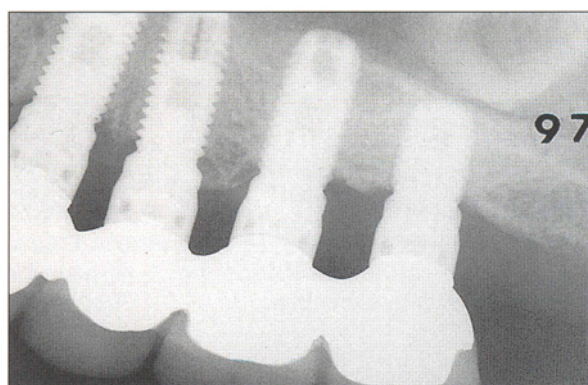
Five-year postoperative radiograph of the implants placed in the previously grafted sinus.
